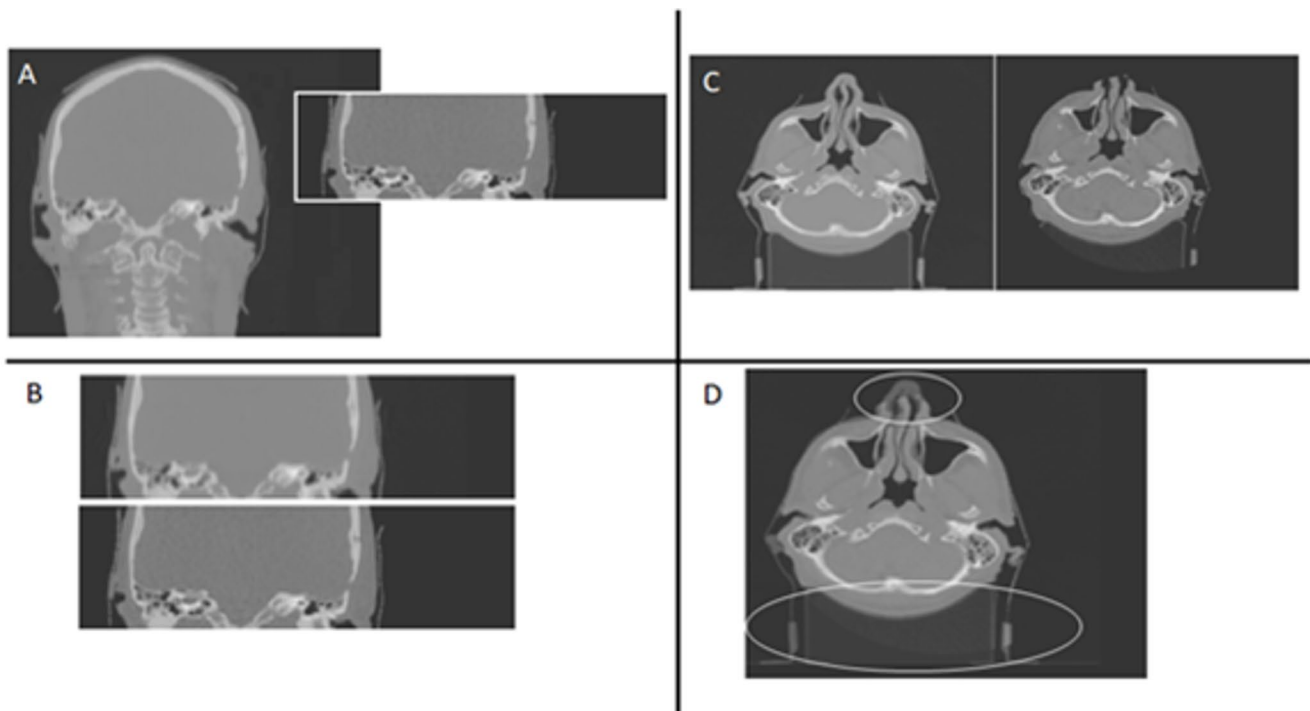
CT and kV-CBCT images of different projections. Unaligned data sets A and C. Aligned data sets B and D
